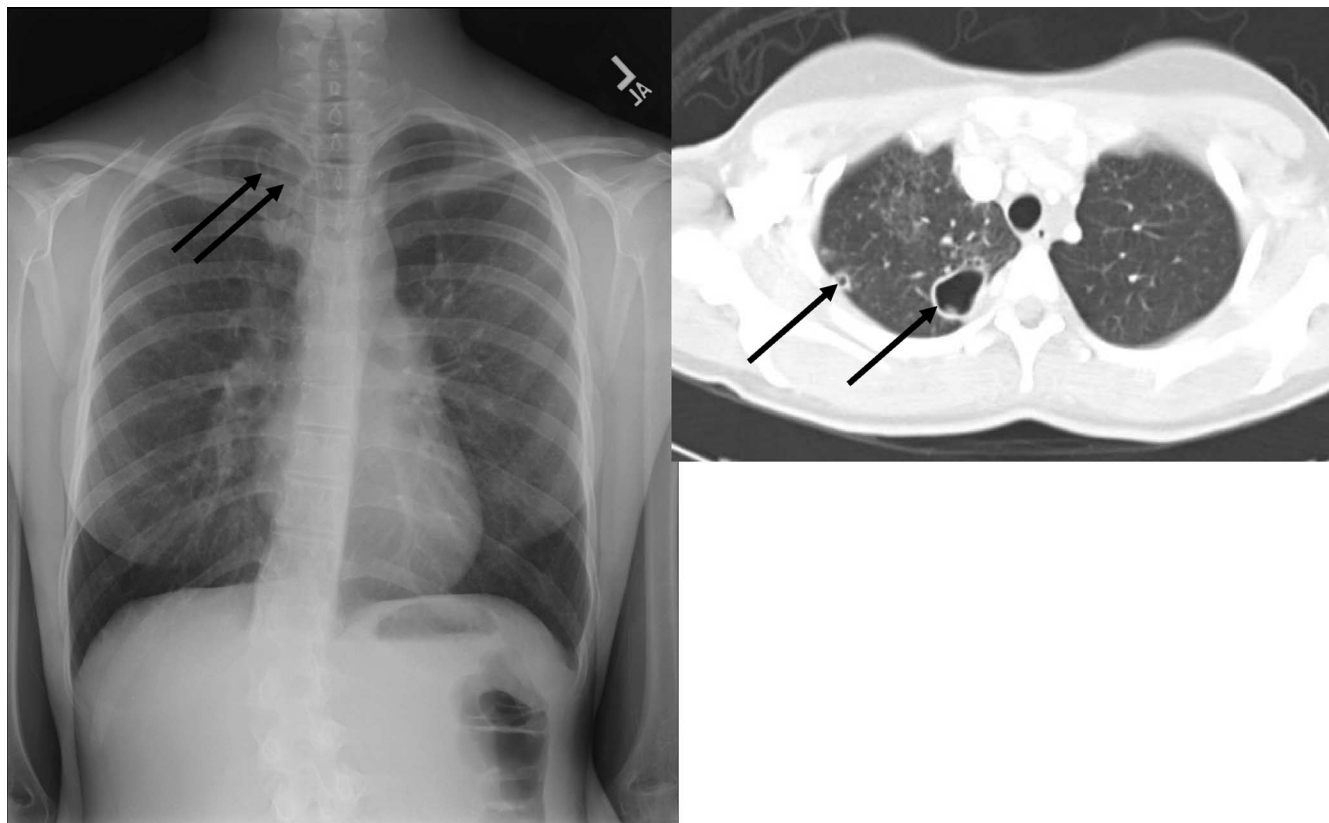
Mycobacterium kansasii* pulmonary disease presenting as 8 months of hemoptysis without any systemic symptoms in a 16-year-old girl. The thin-walled cavities (in the right apex) are relatively subtle on plain chest radiography (left) but are readily apparent by computed tomography, as is the accompanying bronchiectasis (right).
